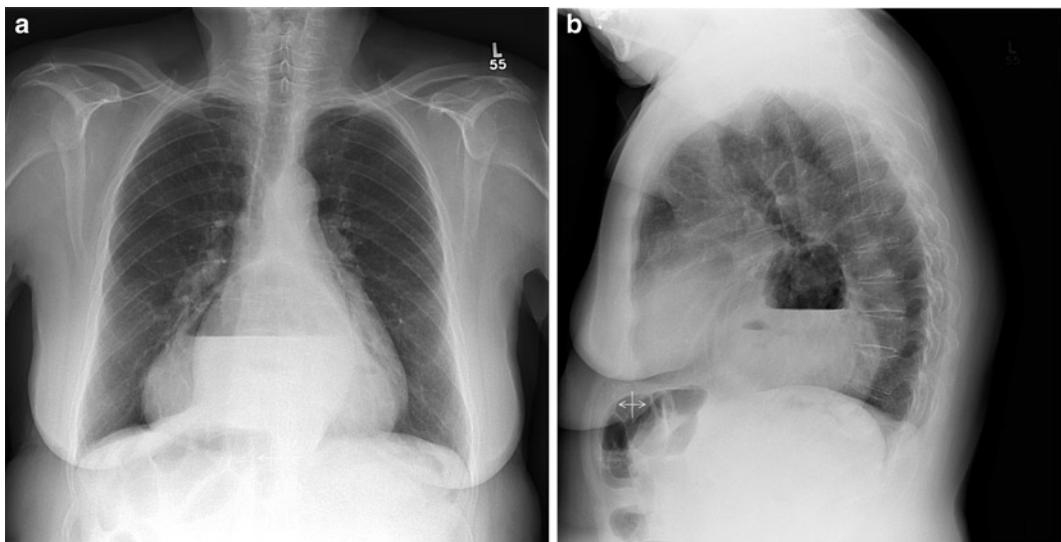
(a) PA and (b) lateral chest X-rays of a patient with an intrathoracic stomach which has herniated through the esophageal hiatus of the diaphragm. The risk of aspiration of gastric contents during induction of anesthesia can be appreciated.
